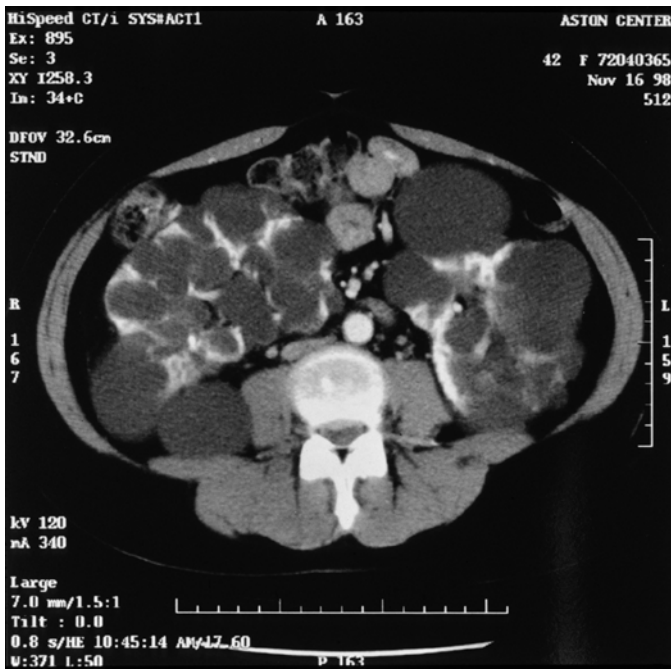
Nonenhanced CT scan for patient with ADPKD.
